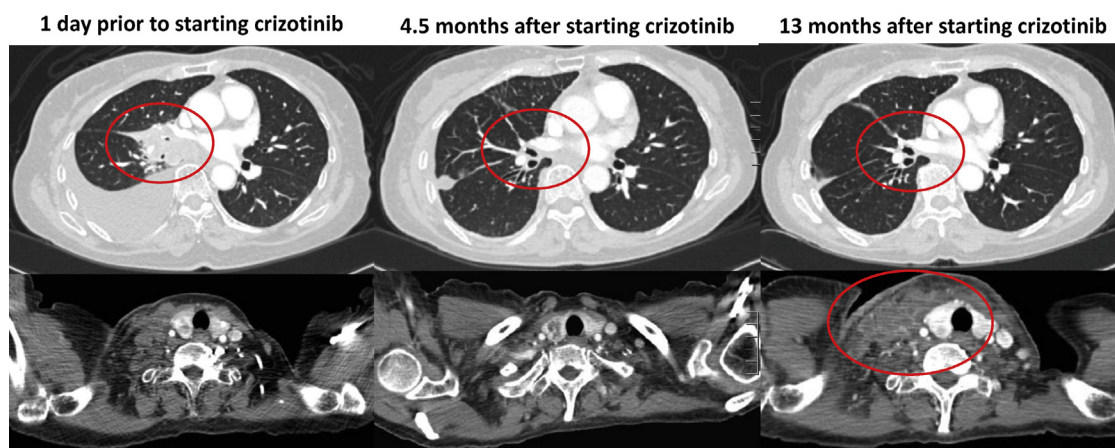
Computed tomography scans of the patient before crizotinib treatment, confirmed response to crizotinib, and at progression during crizotinib treatment.
